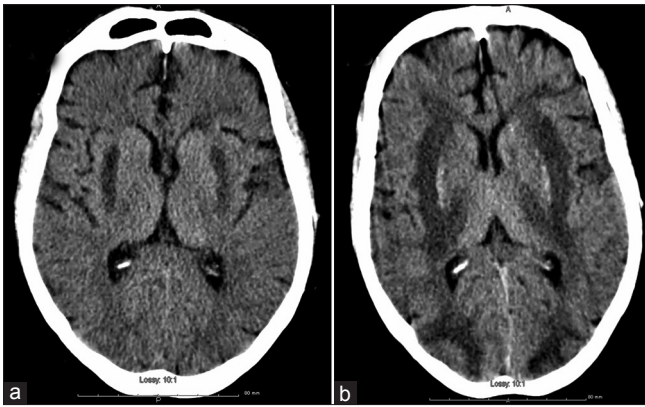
(a) Head computed tomography (CT) showed new hypodense lesions in basal ganglia bilaterally and old small vessel ischemia changes in periventricular matter. (b) New CT of head without contrast demonstrated new hyperdensities in putaminal area compatible with the diagnosis of putaminal hemorrhages
